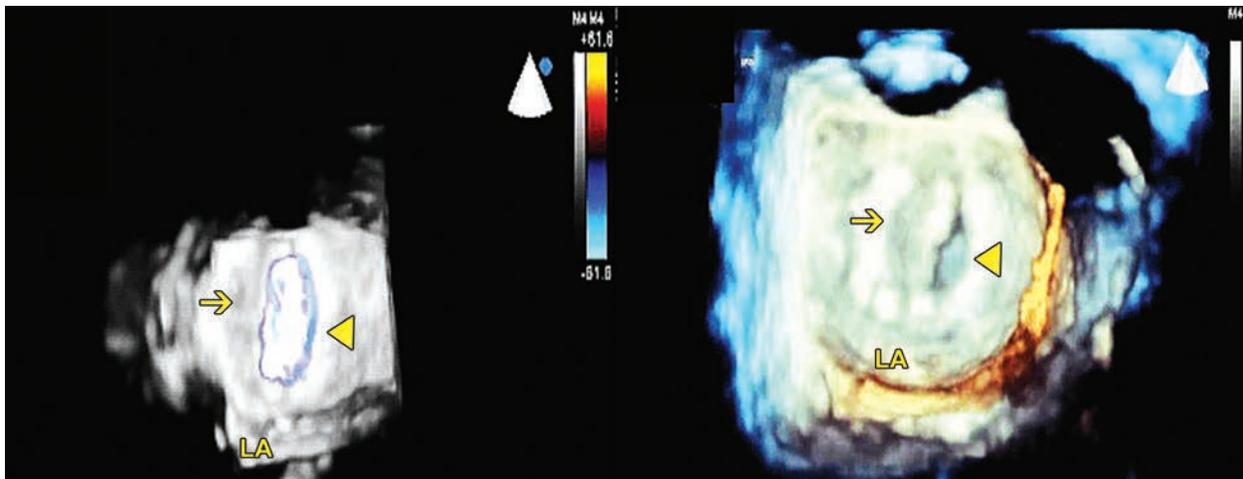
Transesophageal echocardiogram of the valve is crucial in this disease. On the right side of the image, color Doppler demonstrates flow acceleration at the valve plane consistent with mitral stenosis. The left side of the panel demonstrates the immobile leaflet (arrow) and mobile leaflet (arrowhead).
